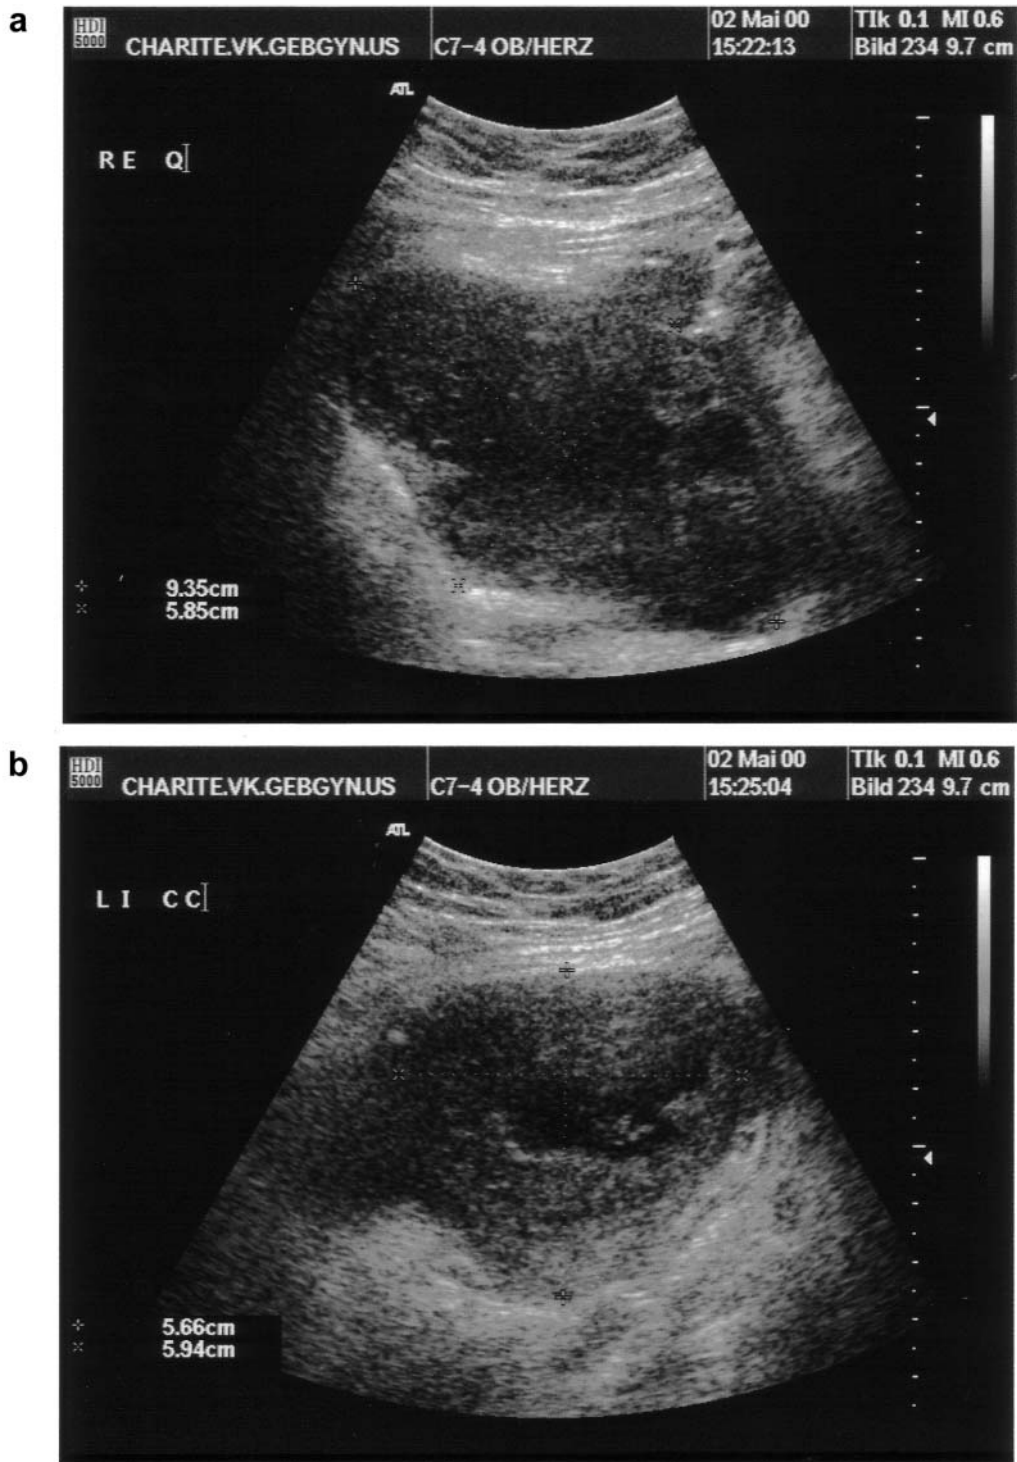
a) Transabdominal sonography of the right adnexal masses. b) Transabdominal sonography of the left adnexal masses.
